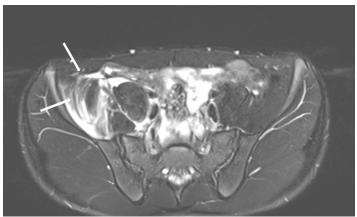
T2-weighted magnetic resonance imaging showing a high-intensity lesion in the right iliac muscle (arrows).
